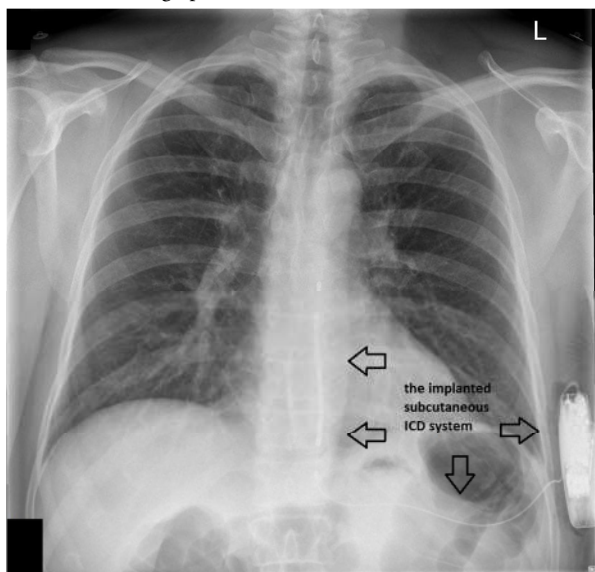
Chest radiograph (PA view) showing the implanted subcutaneous ICD
